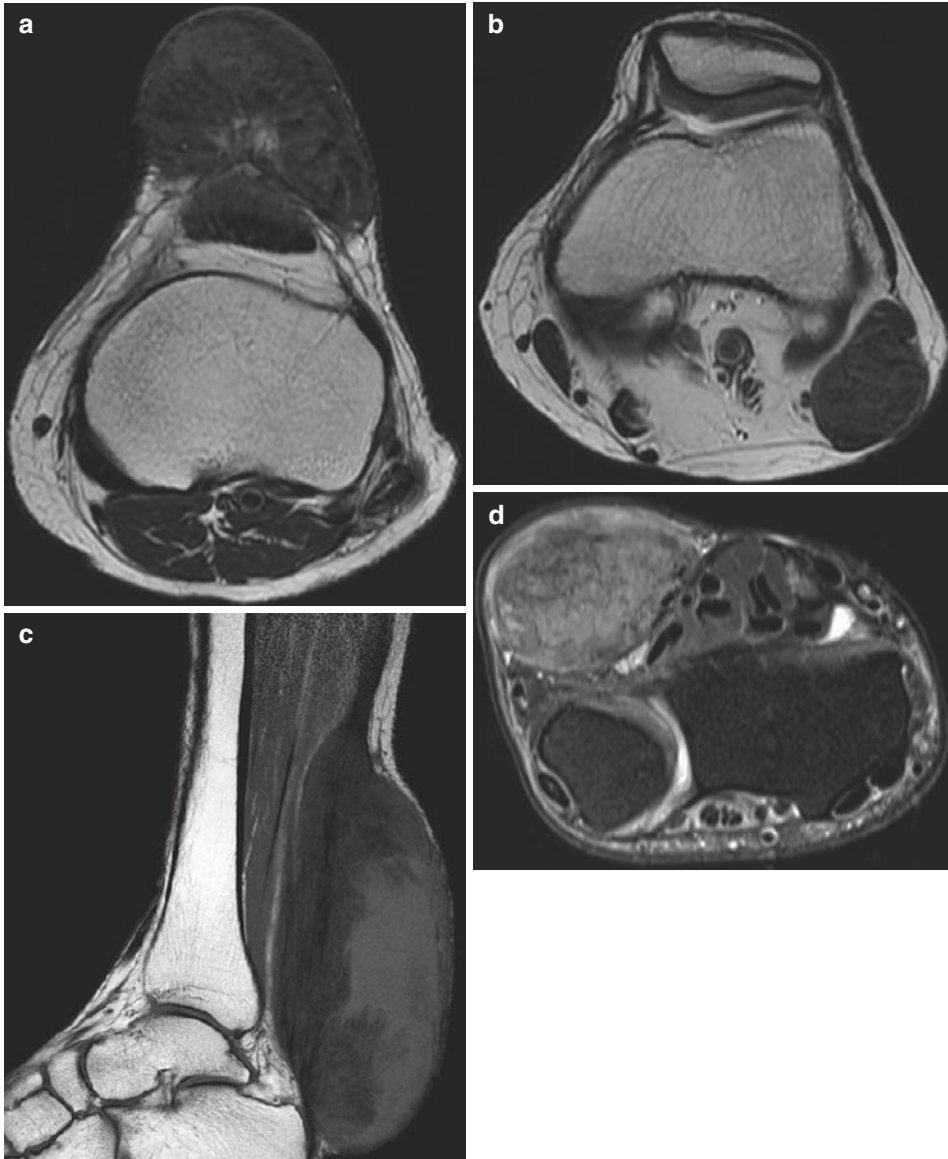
Familial hypercholesterolemia. MR images show hypointense soft tissue masses (tendinous xanthomas) in patellar ligament (a), biceps femoris tendon (b), Achilles tendon (c), and flexor carpi ulnaris (d). Axial
